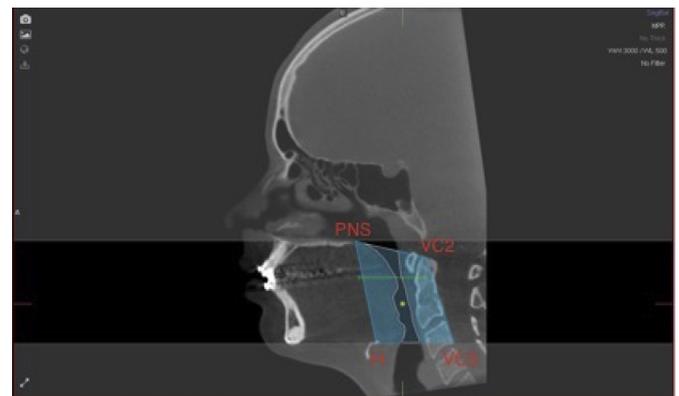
Computed tomography image in a sagittal section showing the area of pharyngeal airspace marked on the trapezoid in green. The region of interest was demarcated by the red line that circumvented the anterior and posterior portion of the pharynx. Posterior nasal spine (PNS); cervical vertebra 2 (VC₂); cervical vertebra 3 (VC₃); and hyoid bone (H).
